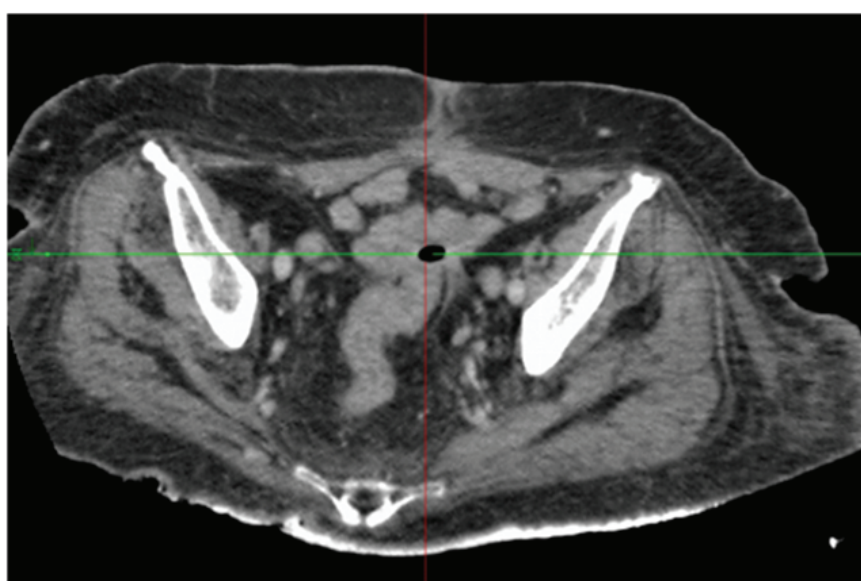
Axial view of the patient's colovaginal fistula on CT imaging
